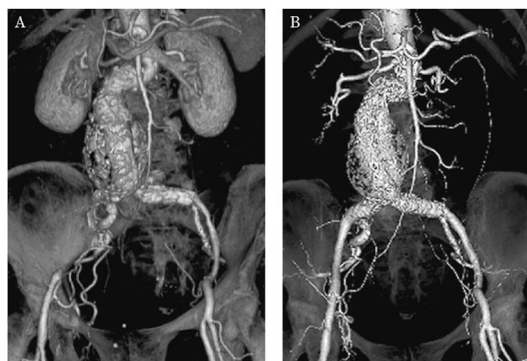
EVAR using bifurcated endoprosthesis with concomitant recanalization of iliac artery occlusion. Patient 5.5-cm abdominal aortic aneurysm and right EIA occlusion. A: Pre-procedure CTA, B: Post-procedure CTA.
